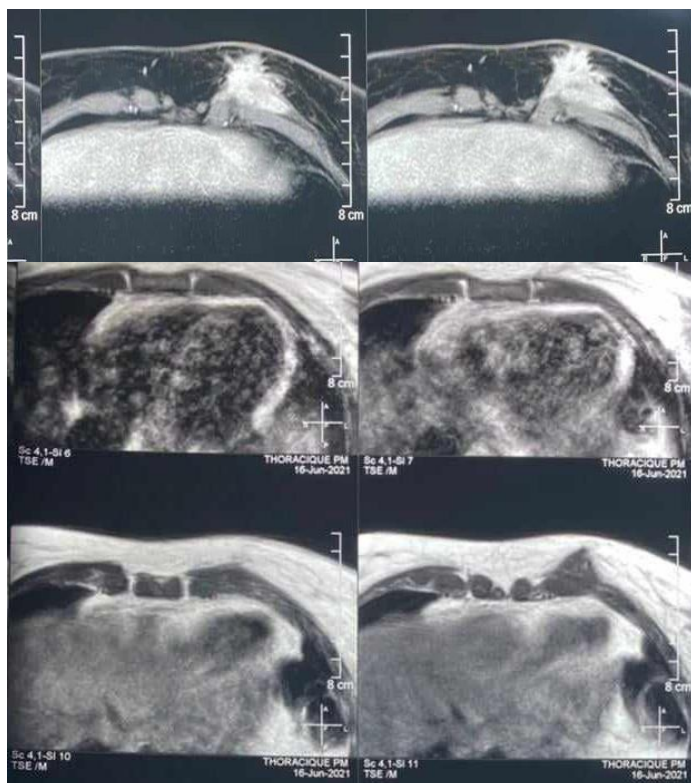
The thoracic MRI showing the tumor mass
